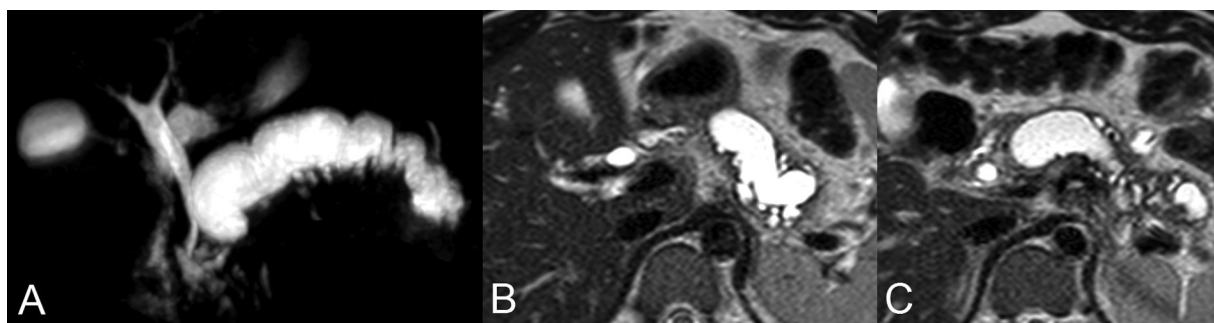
(A) MRCP and (B, C) T2-weighted axial MR images of a patient with main pancreatic duct stenosis at the head of pancreas. Note the severe dilatation of MPD distal to the level of stenosis. MRCP, magnetic resonance cholangiopancreatography.
